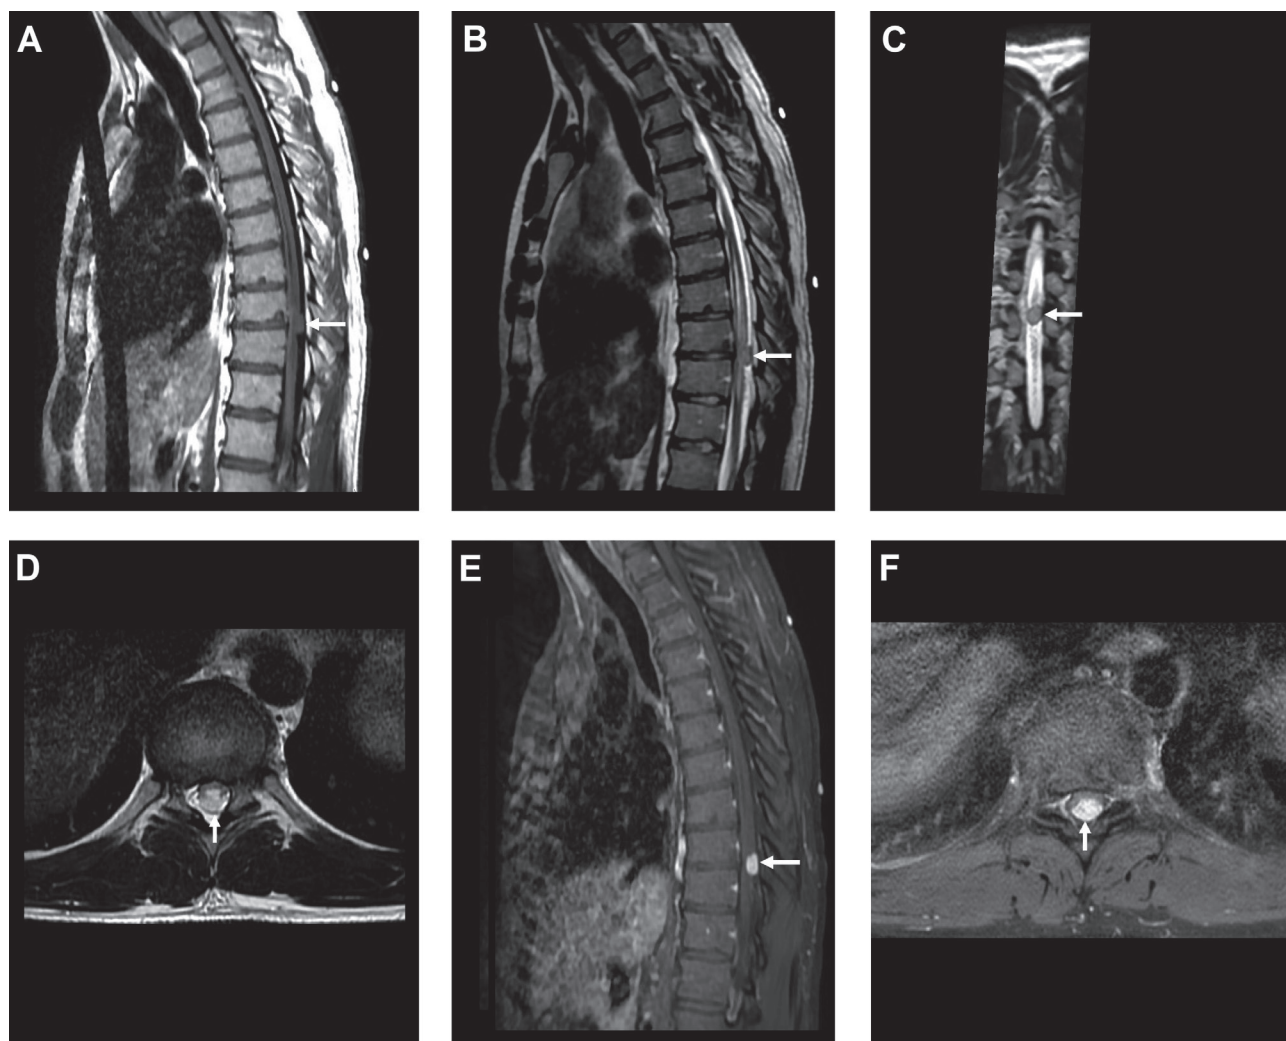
Thoracic spine magnetic resonance imaging. Sagittal T1 weighted-image (A); T2 weighted-image (B); coronal T2 weighted-image (C); axial T2 weighted-image (D); sagittal (E) and axial (F) T1 FAT SAT with contrast. Intradural extramedullary enhancing tumour located dorsally to the spinal cord at the T9-10 level (white arrows), with spinal cord infiltration and spinal cord edema/pre syrinx.
